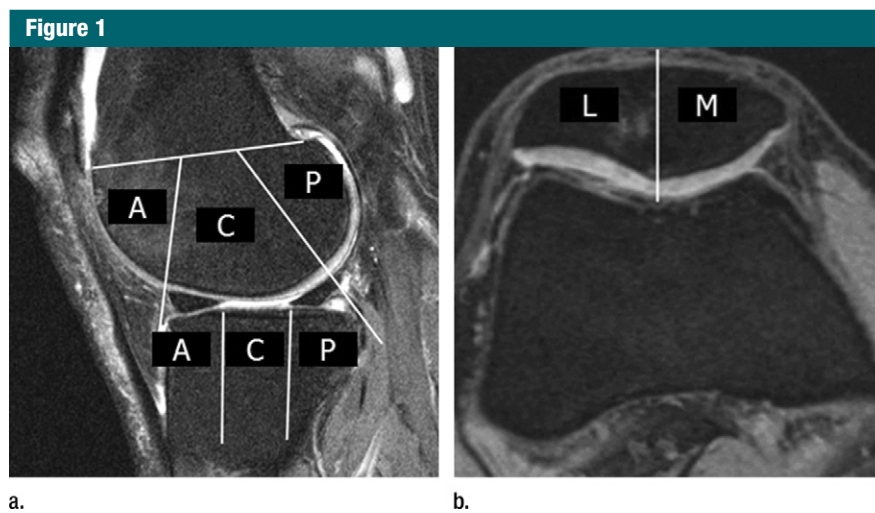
MR images demonstrate subregional joint division by using the MRI Osteoarthritis Knee Score, or MOAKS. (a) Sagittal MR image demonstrates the anatomic delineation of the femur into the anterior (A), central (C), and posterior (P) subregions. The tibia is subdivided into anterior, central, and posterior subregions, which are separated by equal thirds. (b) Axial proton density-weighted MR image shows the subdivision of the patella into the medial (M) and lateral (L) facets (ie, subregions). The patella apex is part of the medial subregion.
